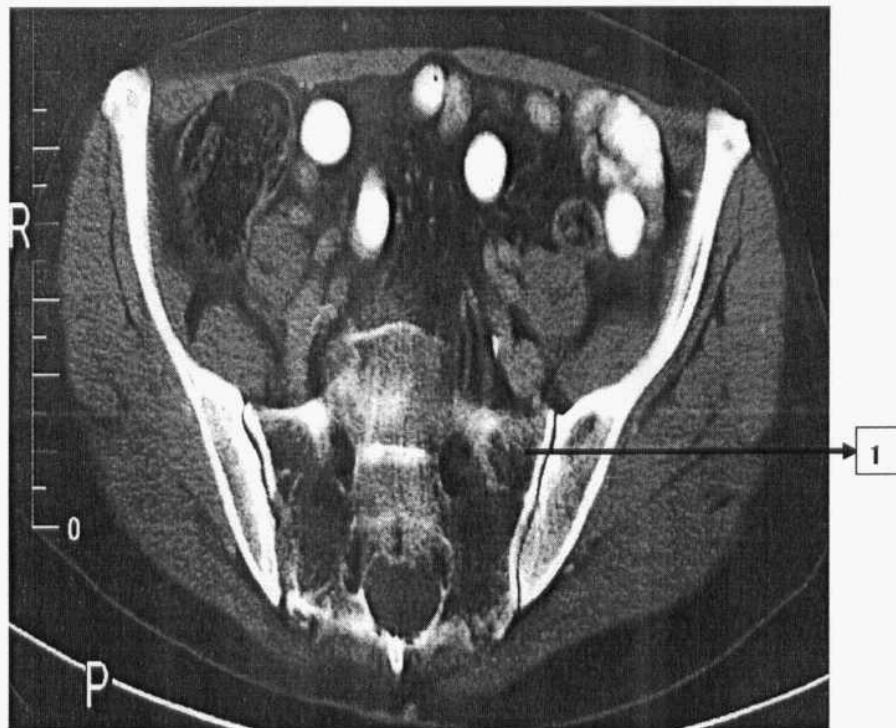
Axial CT of female pelvis
